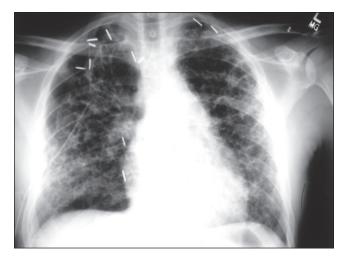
LCH. Posteroanterior chest radiograph demonstrating far advanced cystic and nodular changes throughout the lung parenchyma. A persistent right pneumothorax is evident, despite the presence of a right thoracoscopy tube. Surgical clips are from prior thoracotomies for attempted pleurodesis.
